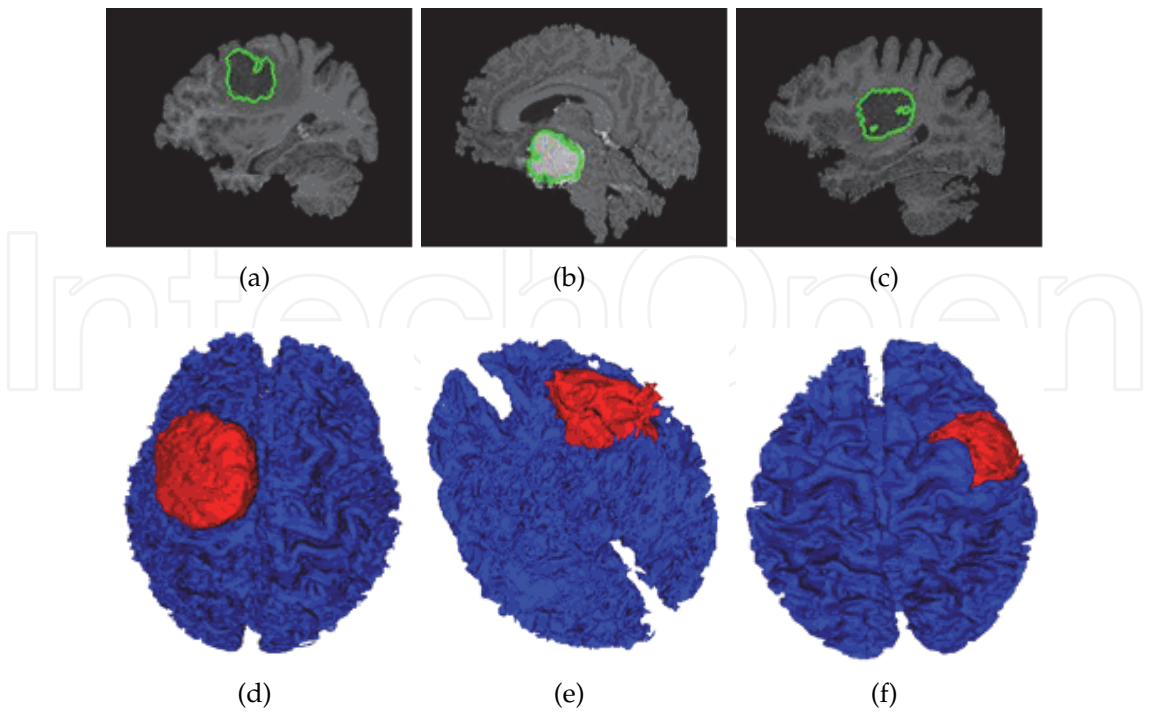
3D visualization of some tumors (red) within the cerebral cortex (blue). These results are obtained by the semi-automatic algorithm on real T1-weighted MR images
